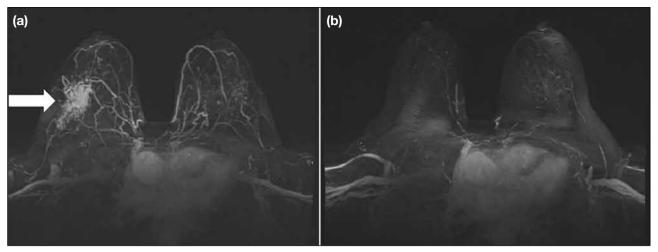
Magnetic resonance images of the same patient as Figure 9 at baseline (a) and post-treatment (b). Interval resolution of right breast index cancer and associated non-mass enhancement (arrow in [a]) was noted.
